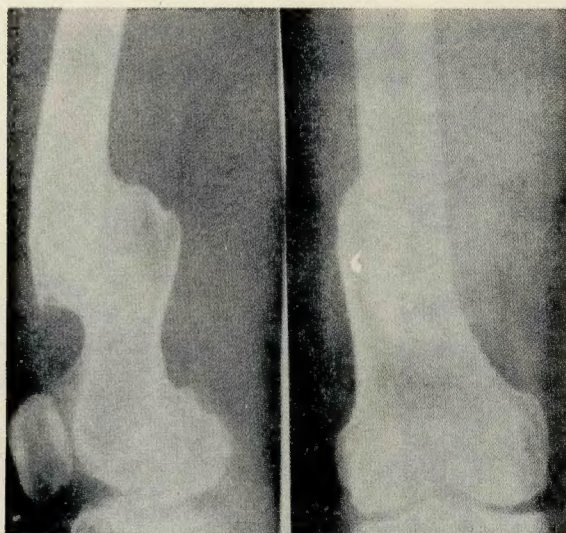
(Record No. 670, I.S.N. 706366) Roentgenogram showing malunion of lower third of right femur.
